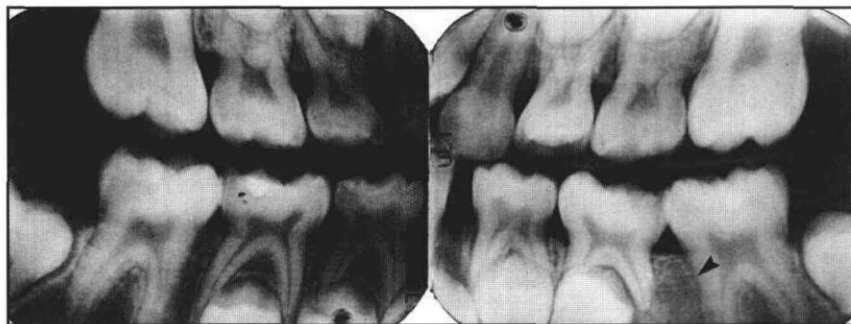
Bite-wing radiographs (4 months postoperative) showing bony fill apical to mandibular left first permanent and second primary molars (arrow).
